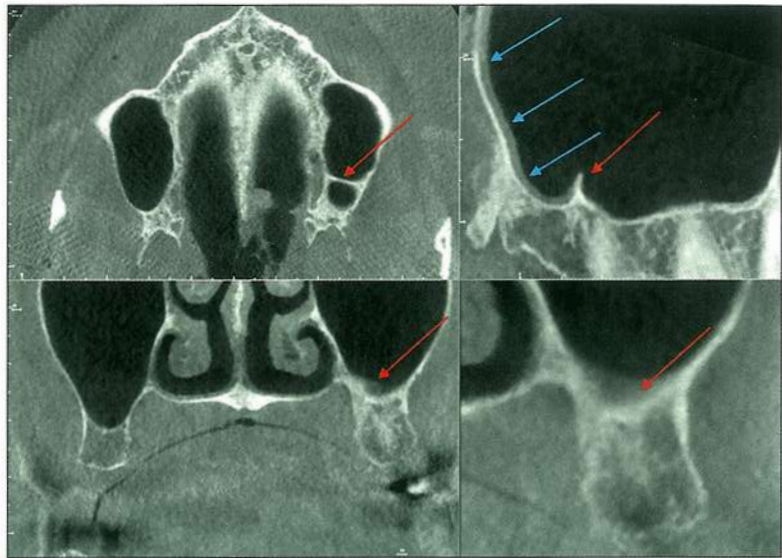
A small sinus septum is present on this CBCT image (red arrows). The sinus membrane is also visible on this reconstruction (blue arrows).
